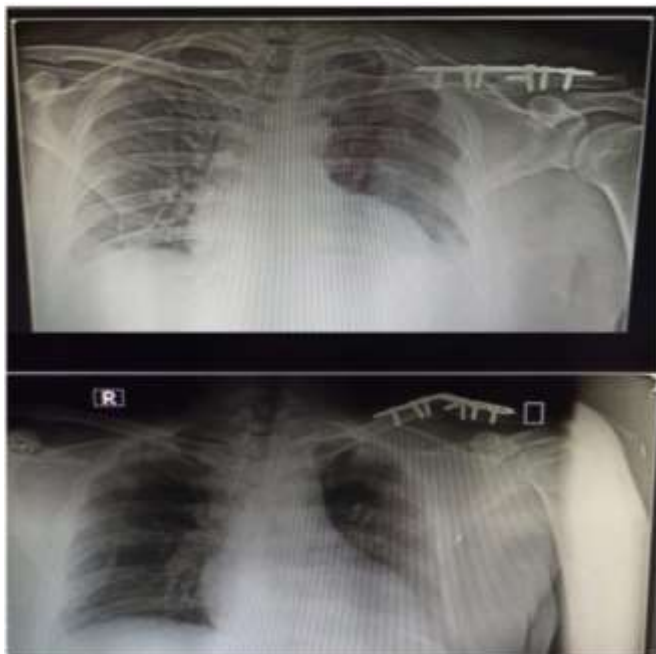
Radiograph of a 45 yr male showing implant failure with delayed union
